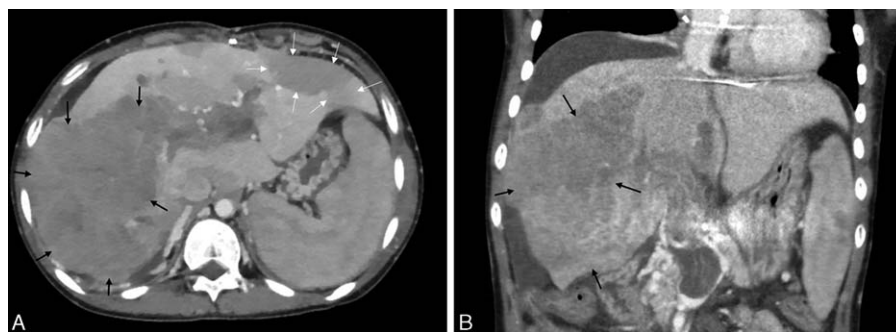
Abdominal CT images show a large mass in the right hepatic lobe (black arrow, 12.5 × 10.5 × 7.5 cm) and multiple masses in the left lobe (white arrow): (A) axial view, (B) coronal view. CT = computed tomography.
